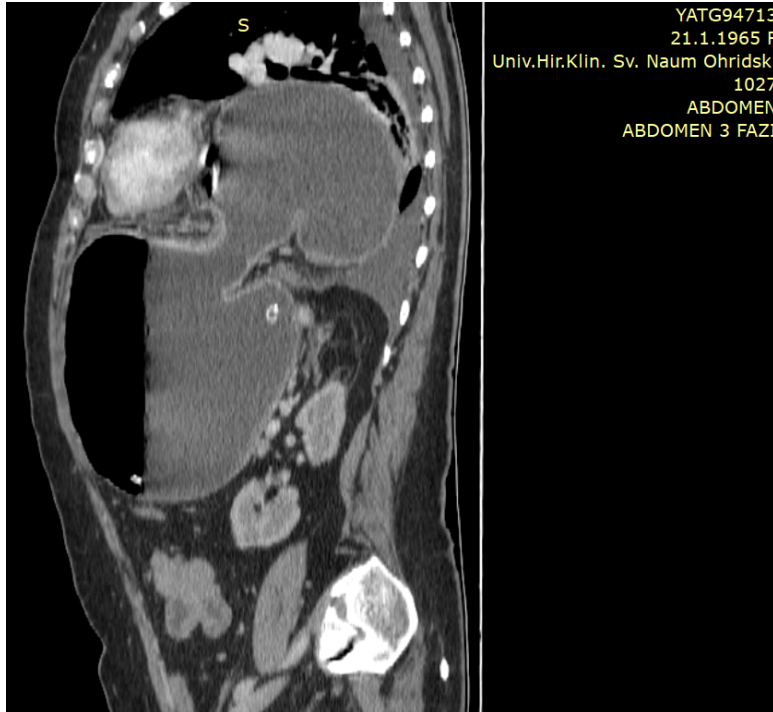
Presentation of the mesenteroaxial volvulus of the stomach on contrast-enhanced CT in sagittal plane with the antropyloric part positioned superiorly and gastro-esophageal junction positioned inferiorly.
